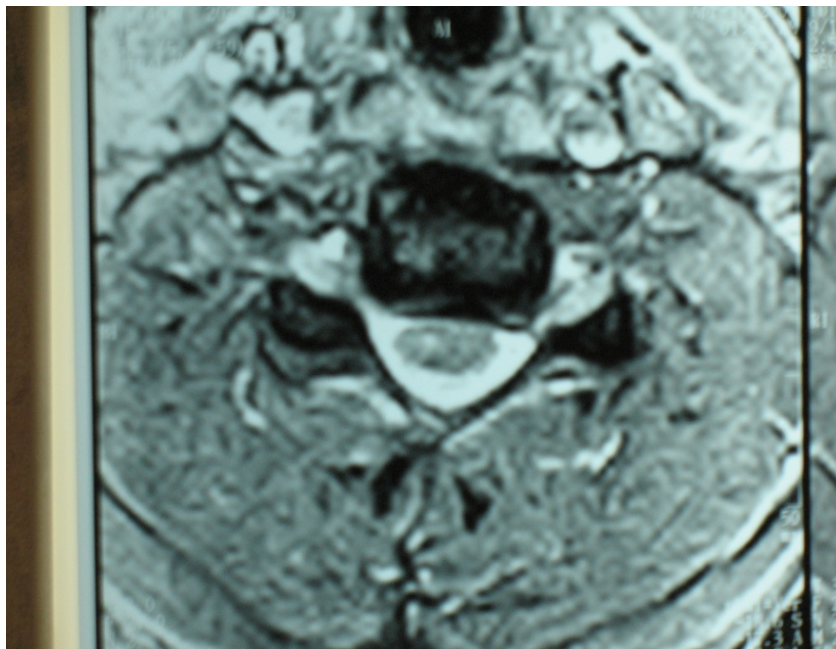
Cervical spine MRI, axial view. C5-C6 level.
